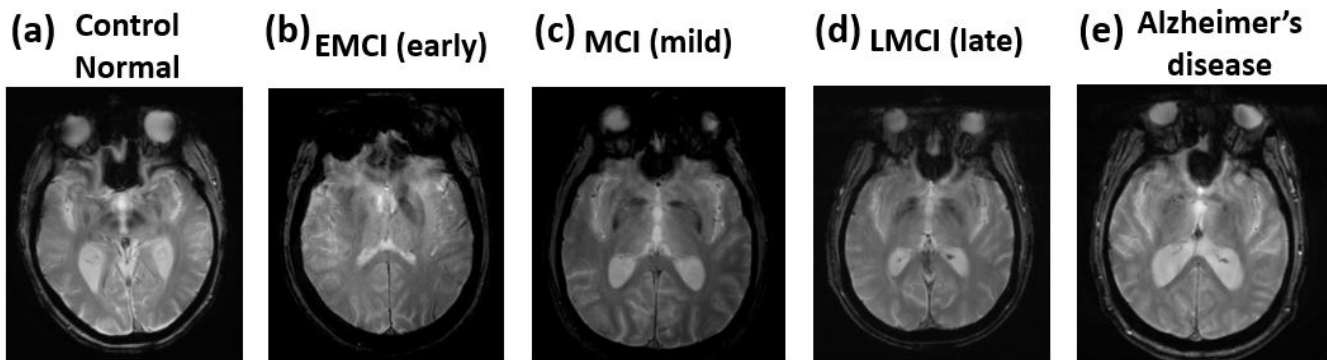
Example of ADNI MRI images at various stages. (a) Control Normal (b) Early Mild Cognitive Impairment (EMCI) (c) Mild Cognitive Impairment (MCI) (d) Late Mild Cognitive Impairment (LMCI), and (e) AD (AD).
